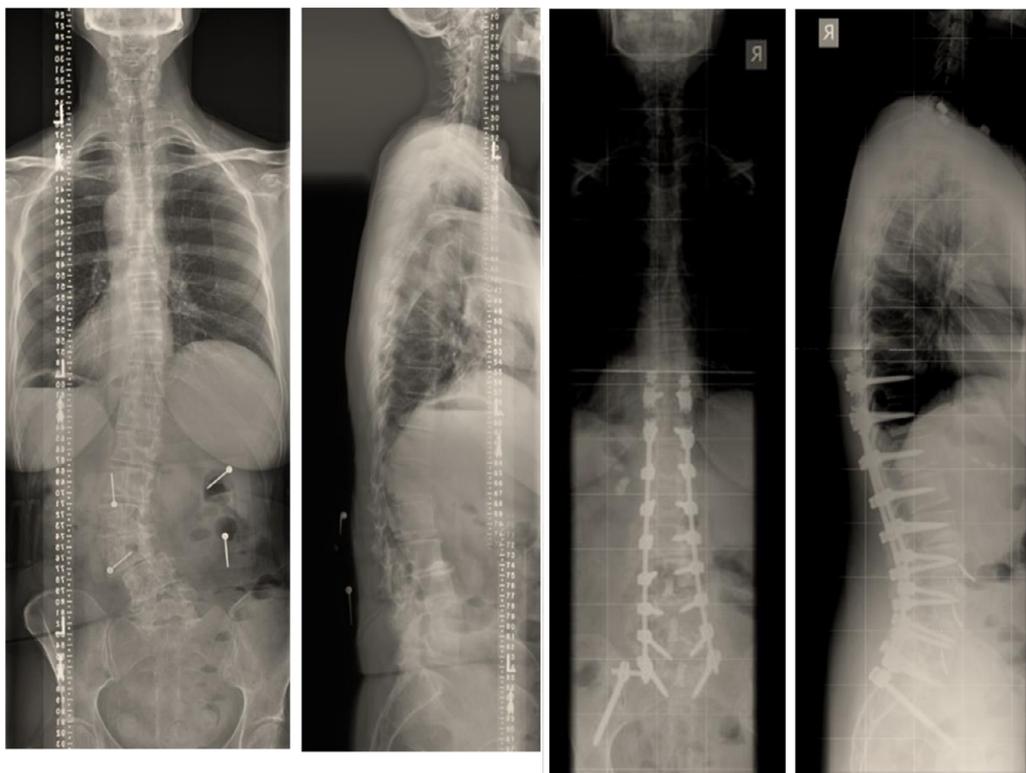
Preoperative and postoperative radiographs of a patient with a type 2 coronal plane deformity. (Color version of figure is available online.)
